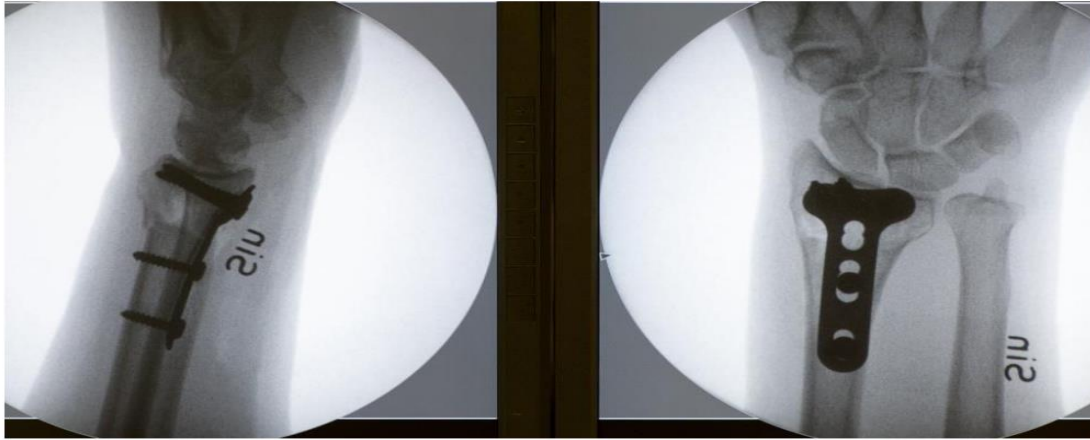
RADIOGRAPHS AFTER VOLAR LOCKING PLATE FIXATION OF A DRF, LATERAL AND APVIEWS
